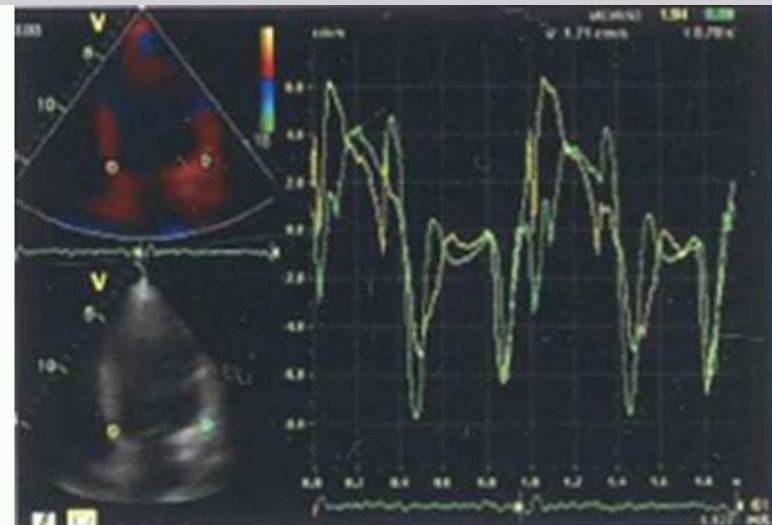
Example of left ventricular (LV) dyssynchrony assessment in a patient. (A) The color-coded tissue Doppler images four-chamber view. The velocity graphs are presented in the right panel of A. There is extensive LV dyssynchrony with a septal-to-lateral delay in peak systolic velocities of 115 ms (arrows). The accompanying velocity encoded magnetic resonance imaging and velocity graphs are presented in panels B and C, respectively, confirming extensive LV dyssynchrony with a septal-to-lateral delay of 116 ms.
